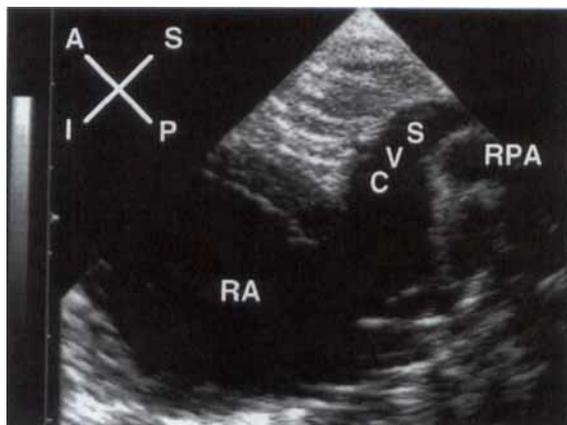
Right parasternal image of a dilated superior vena cava (SVC) recorded from an infant with supracardiac total anomalous pulmonary venous connection. RA = right atrium; RPA = right pulmonary artery. Compass: A = anterior; I = inferior; P = posterior; S = superior.
